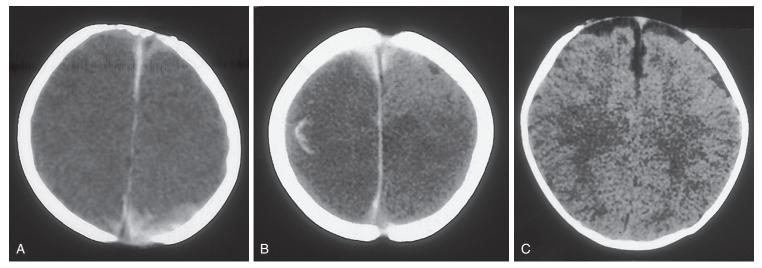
Diffuse axonal shearing. A, Loss of gray/white matter differentiation is evident on this 7-week-old infant's CT scan, along with focal subdural blood around the left occipital lobe and an interhemispheric subdural hematoma. B, This arc-shaped hemorrhage seen in a 2-month-old infant, who also has loss of gray/white matter differentiation, is located at the gray/white interface. This is a sign found occasionally with diffuse axonal shearing injuries. Note the frontal subdural hematoma. C, This CT scan of a normal 2-month-old shows normal gray/white matter differentiation.
